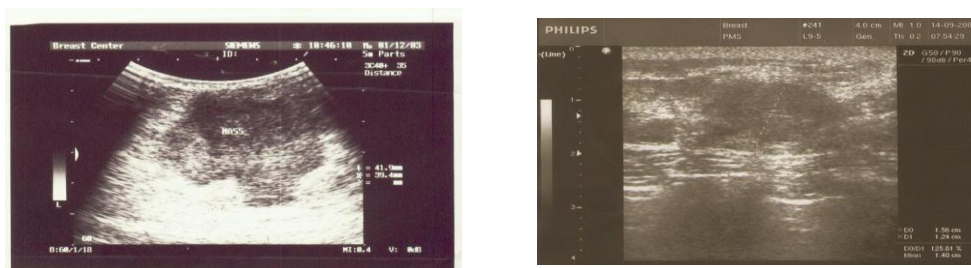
Fibroadenoma with nonhomogeneous echotexture. Sonogram shows a well-circumscribed, elongated fibroadenoma Echotexture is nonhomogeneous with echogenic areas on a hypoechoic background.
